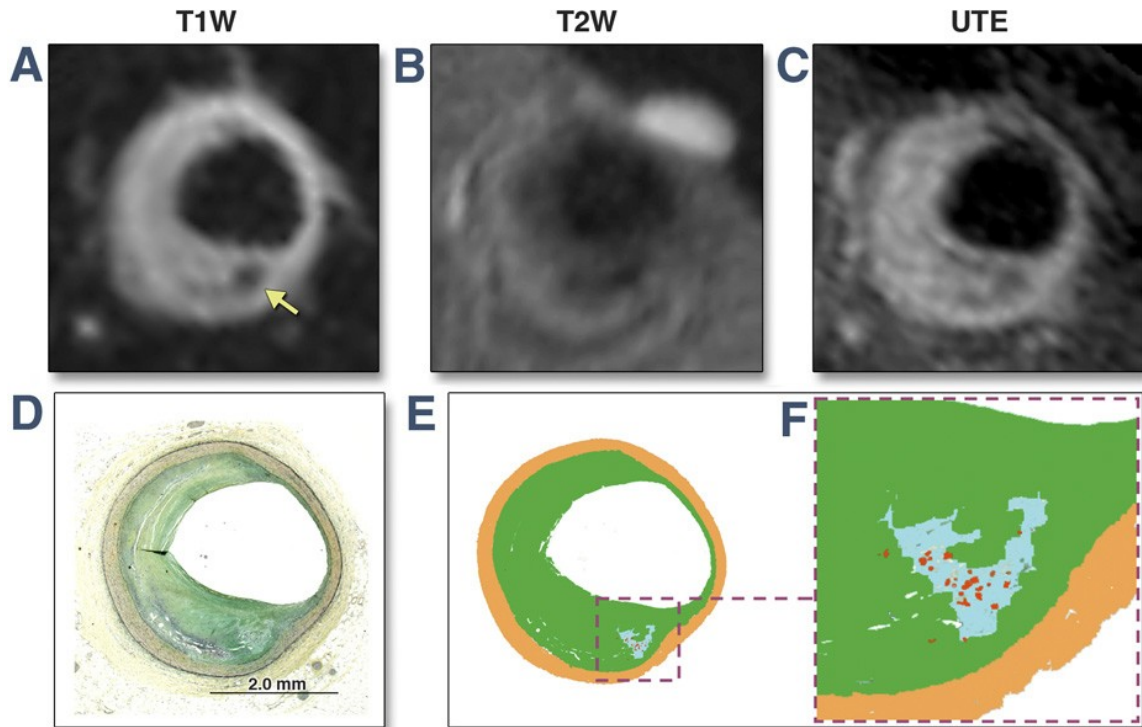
Example of plaque misclassification by MRI.
